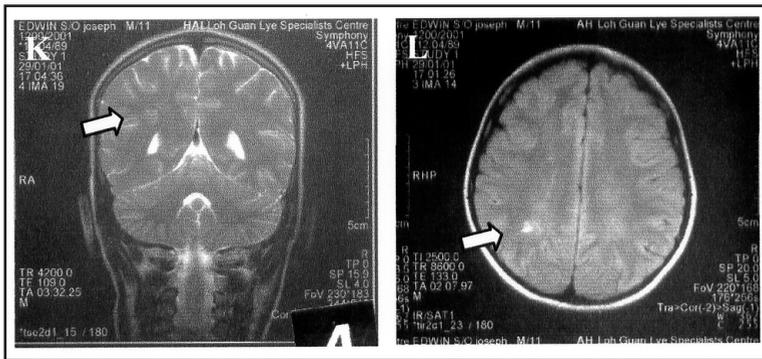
(Case 5): Magnetic resonance T2 weighted coronal (K) and axial FLAIR (L) sequence images showing subtle hyperintense signals in the white matter of the parietal lobes (white arrows).
